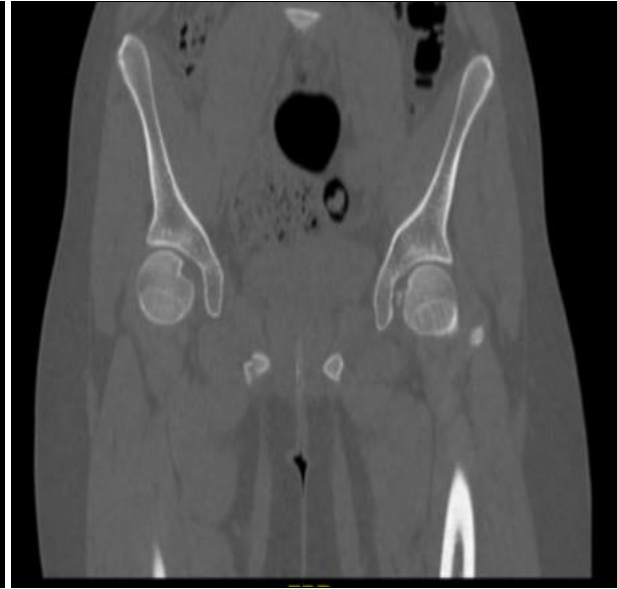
Axial Pelvis CT scan showing a fragment of the avulsed femur head fracture
